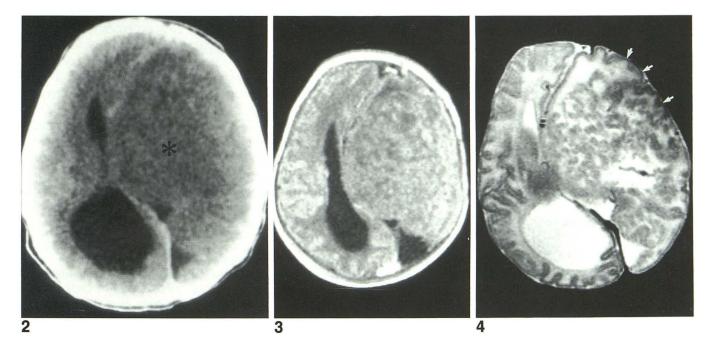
Contrast-enhanced CT section shows the lesion to contain multiple areas of attenuation similar to those of gray and white matter. The lesion does not enhance.
